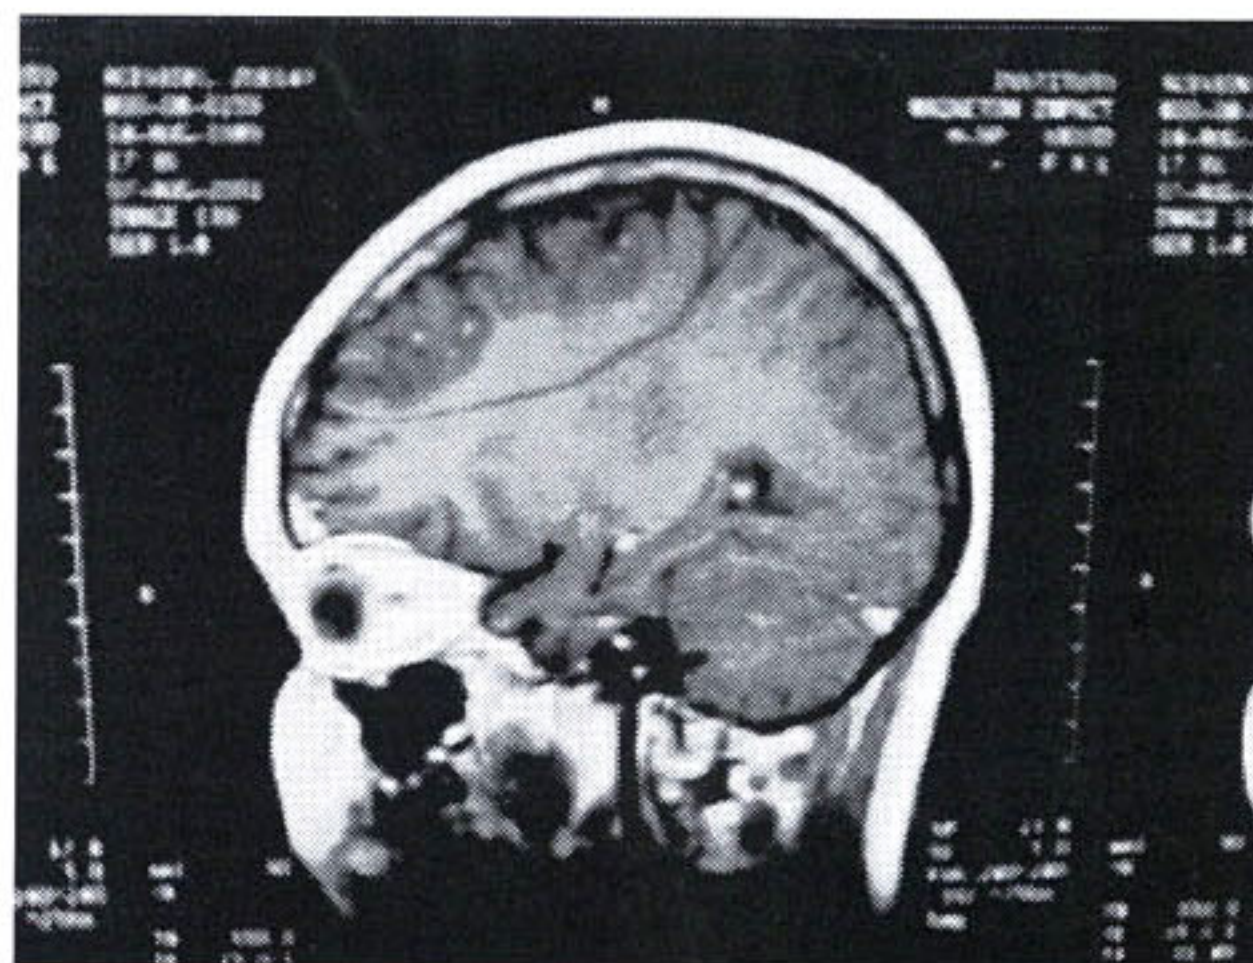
Magnetic resonance image obtained before treatment depicting the lesion of subcortical matter without evidence of hemorrhage
